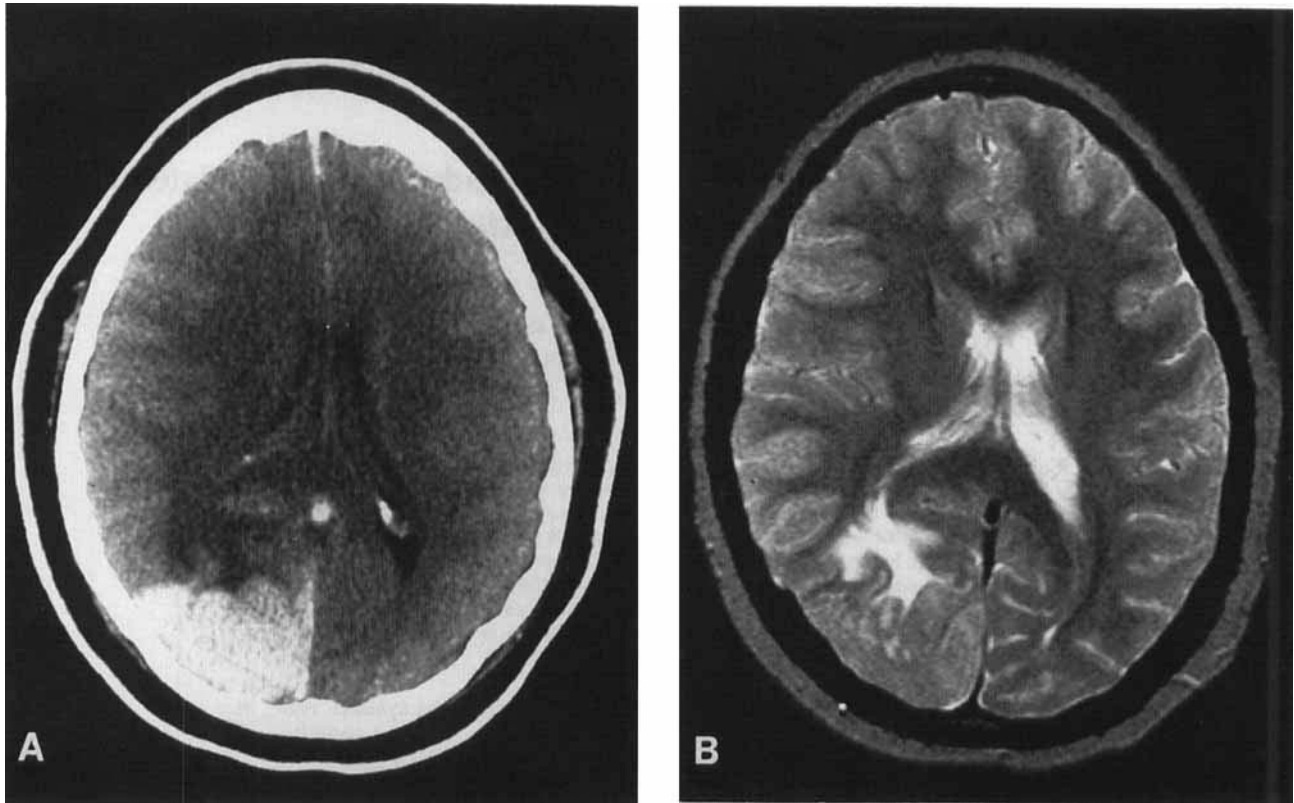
Neuroimaging findings of recurrent isolated CNS leukemia. A. Post-contrast CT shows intense, homogeneous enhancement within the tumor. B. Axial T₂ image shows increased signal intensity in edematous white matter. The tumor mass remains of relatively low signal intensity due to hypercellularity.
